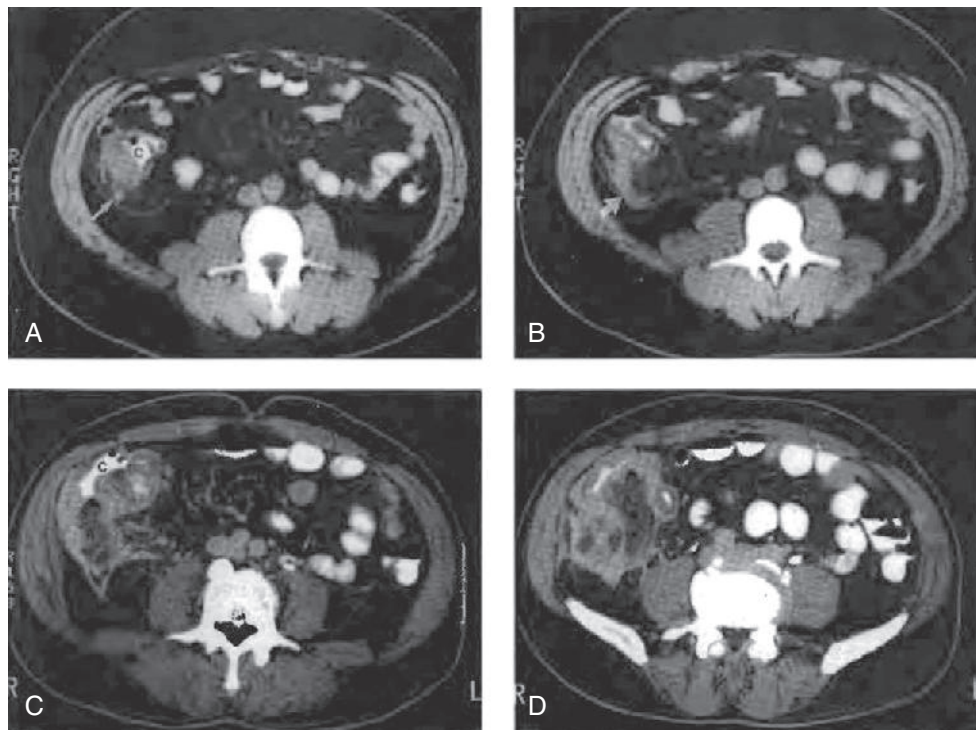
Computed tomography (CT) of acute appendicitis. A, CT scan of uncomplicated appendicitis shows an appendicolith (arrow). B, CT scan shows a dilated appendix (arrow) and surrounding inflammation in the pericecal fat. C and D, Two views at different levels of perforated appendicitis with abscess formation. C, Cecum. (From Novelline RA, editor: *Squire's fundamentals of radiology*, ed 6, Cambridge, Mass., 1964, Harvard University Press, Figures 13.43 and 13.44.)
